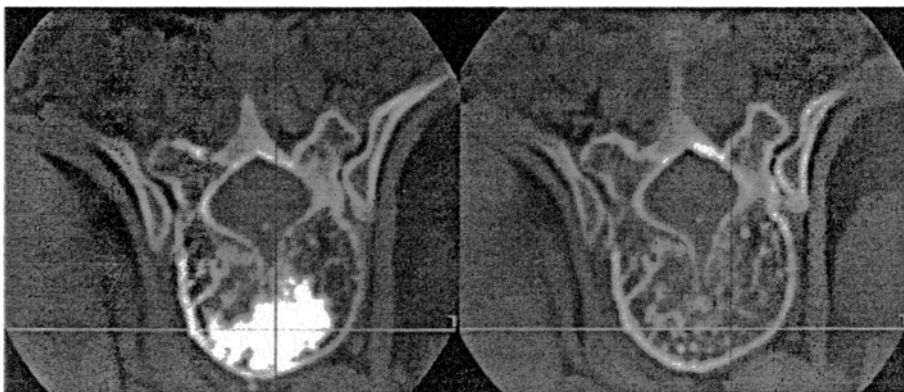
CT images taken before (right) and after (left) percutaneous injection of PMMA. The radiopaque area in the left image indicates the region of bone cement injection
